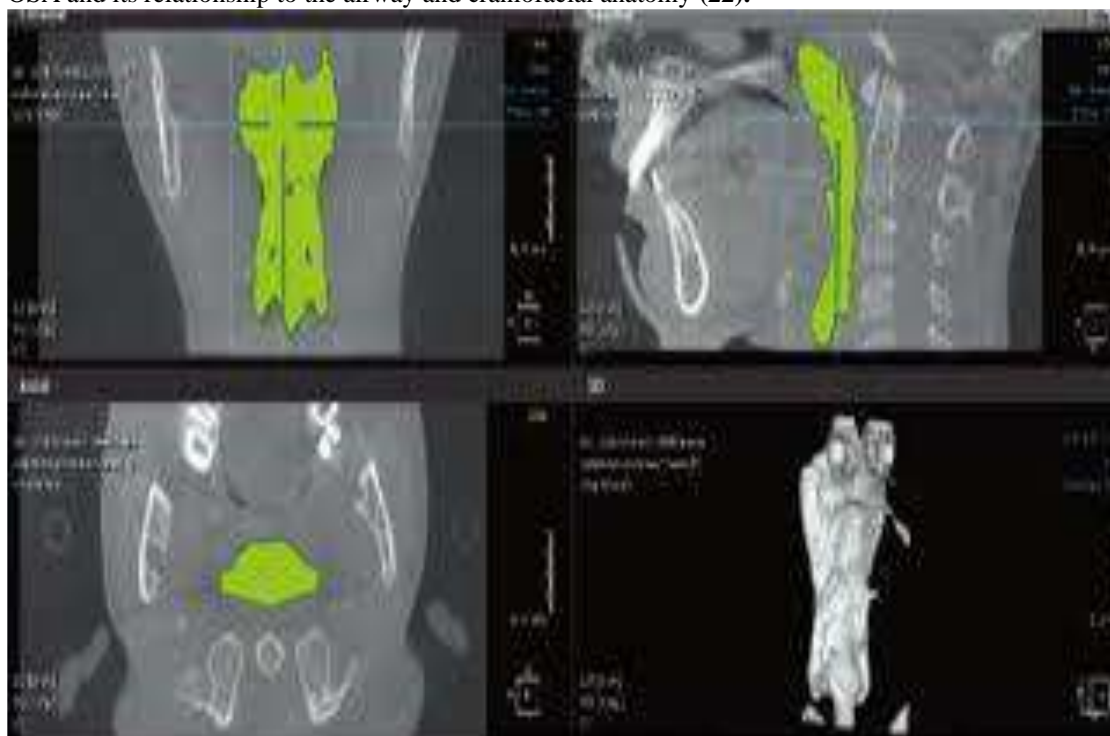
CBCT image revealing a defined and colored pharyngeal airway space (green clour) in the axial, coronal and sagittal
